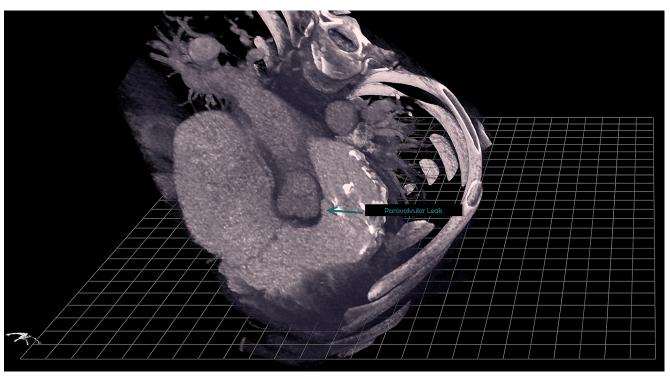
Computed tomography viewed on True3D Viewer (Echopixel, Inc., Mountain View, CA) showing paravalvular tunnel in the posteromedial side of the pulmonary valve.
